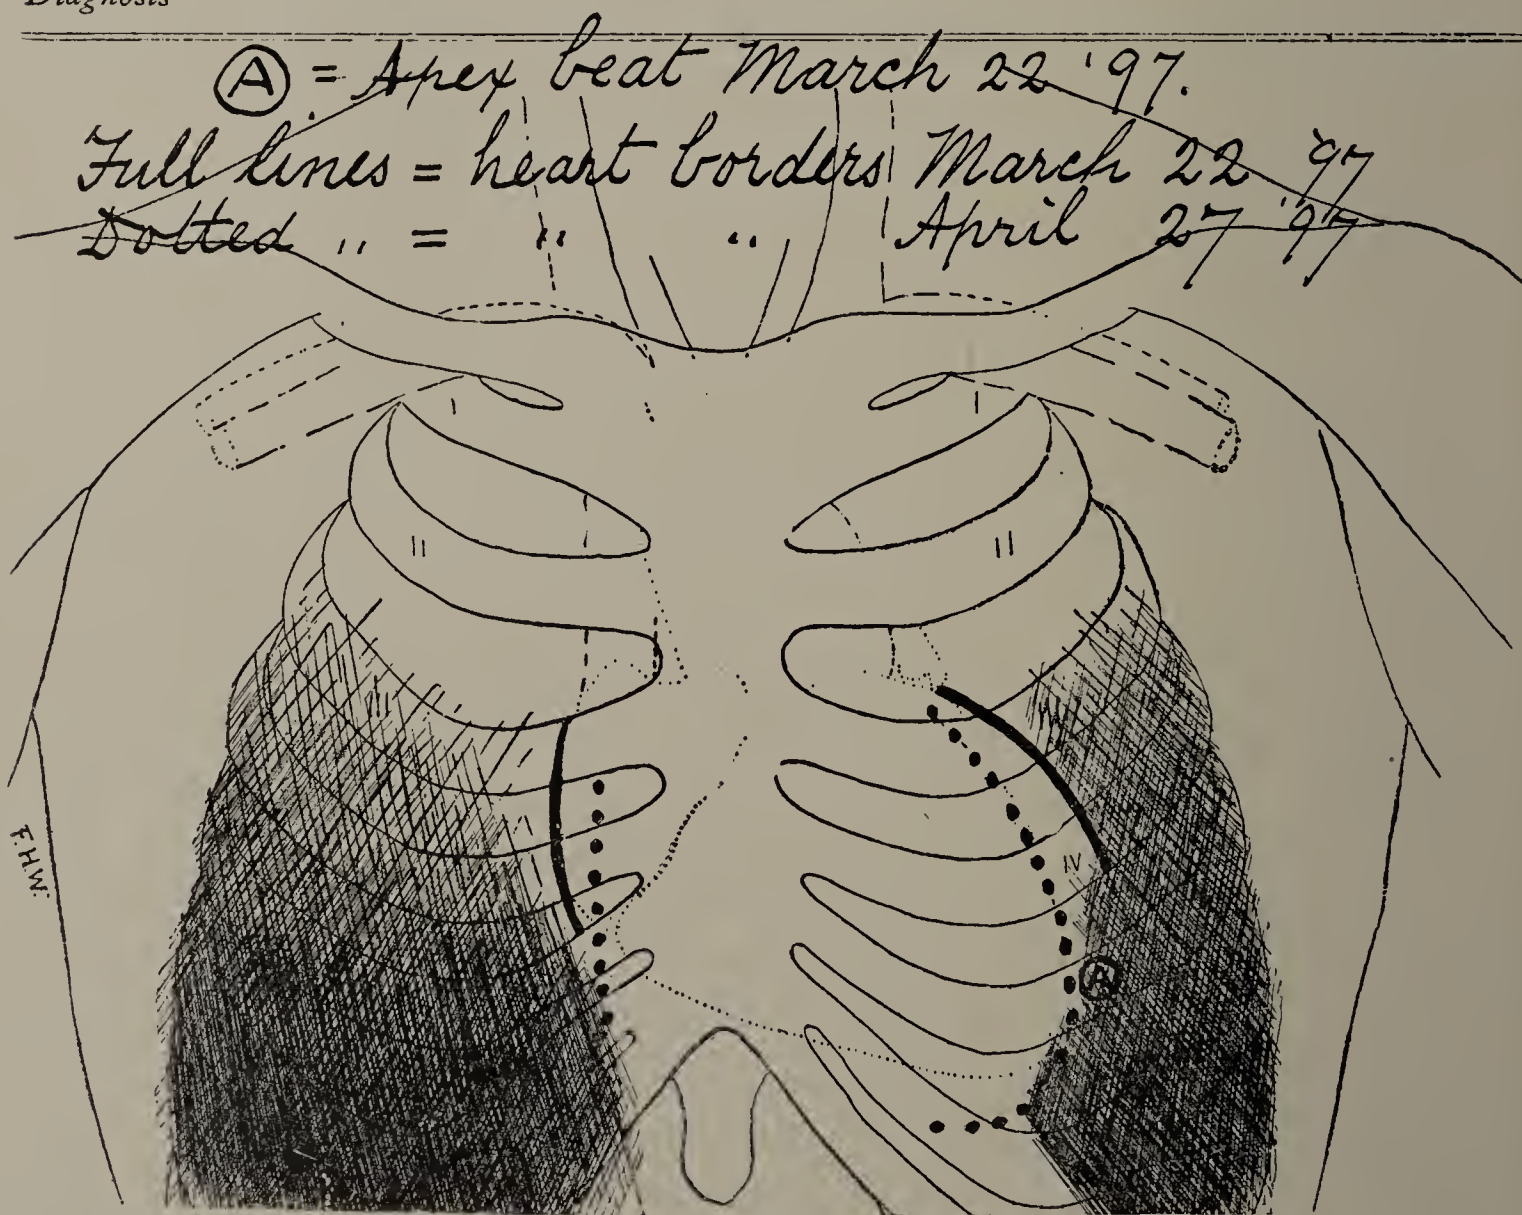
Ella H. First X-ray examination. (Cut one-third life size.) Both lungs dark except in upper portions. Heart enlarged.
